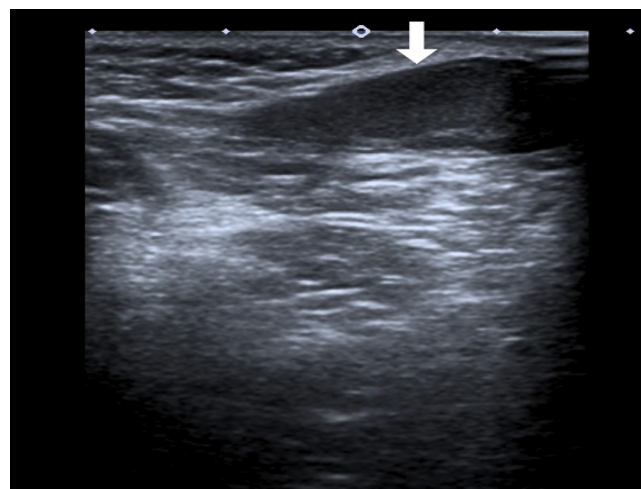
Ultrasonography 1
